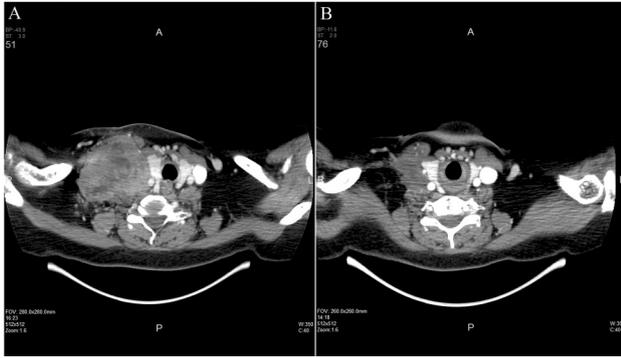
Axial image of contrast enhanced CT scan of the neck showing. (A) Heterogeneously enhancing well defined right supraclavicular mass (6.5×5.5 cm), displacing the trachea to the left without airway obstruction. Displacement of the thyroid gland and right common carotid artery can be seen. (B) Substantial resolution of the bulk of the right supraclavicular mass and substantial resolution of the mass-effect on the trachea and neck structures. Residual ill-defined soft tissue mass (3.1×1.6 cm) can be seen.
